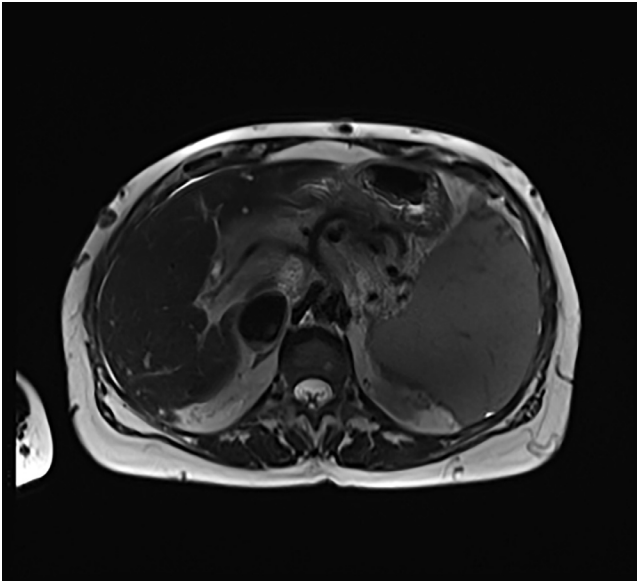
Axial T2 MRI demonstrates a T2 hyperintense, mildly enhancing porta-hepatis mass.
